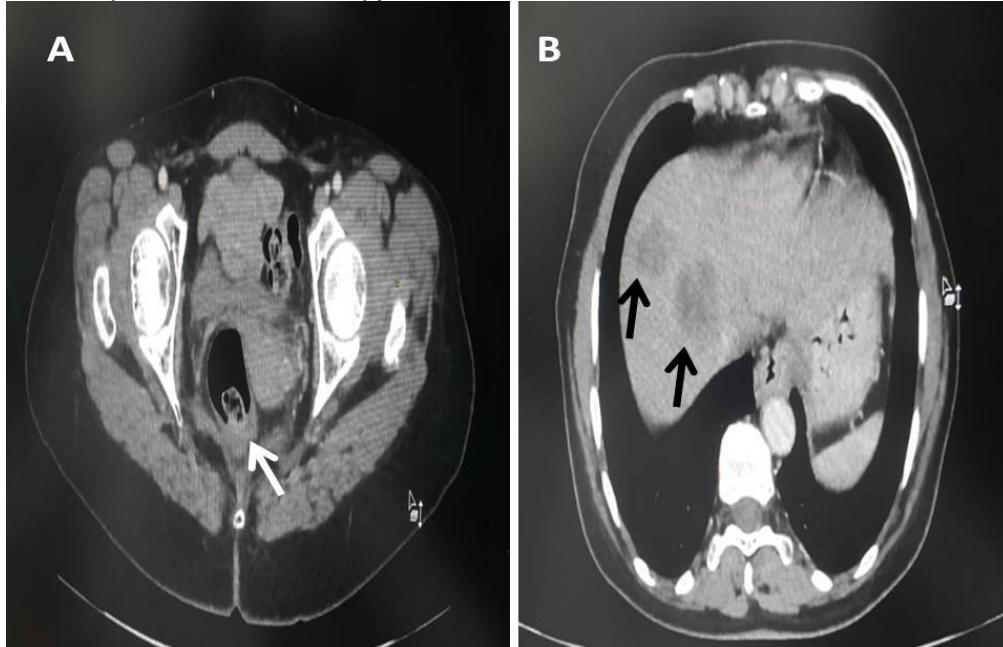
CT scan of abdomen and pelvis revealing rectum wall thickening (Panel A, black arrow) and colorectal liver metastases (Panel B, white arrows)
